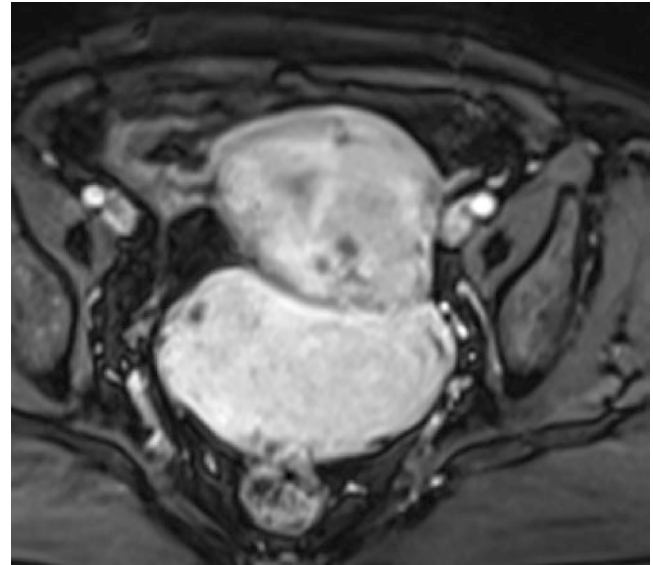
Leiomyosarcoma of uterus. On DWI, the mass showed enhanced homogeneously on contrast-enhanced images
